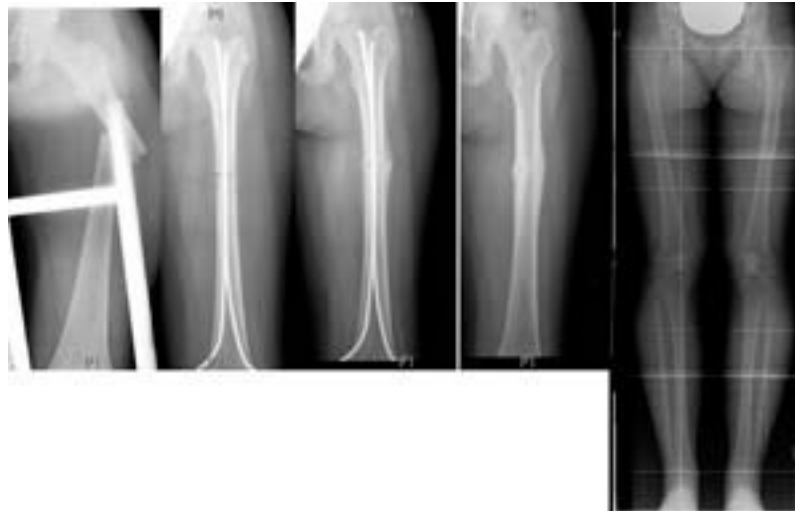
Thirteen-year-old female with a fracture of the left middle third of the femur. Treatment with TENSnails. X-ray control at one month, 3 months, one year, and at 2 years after fracture showed perfect consolidation without femoral overgrowth.
